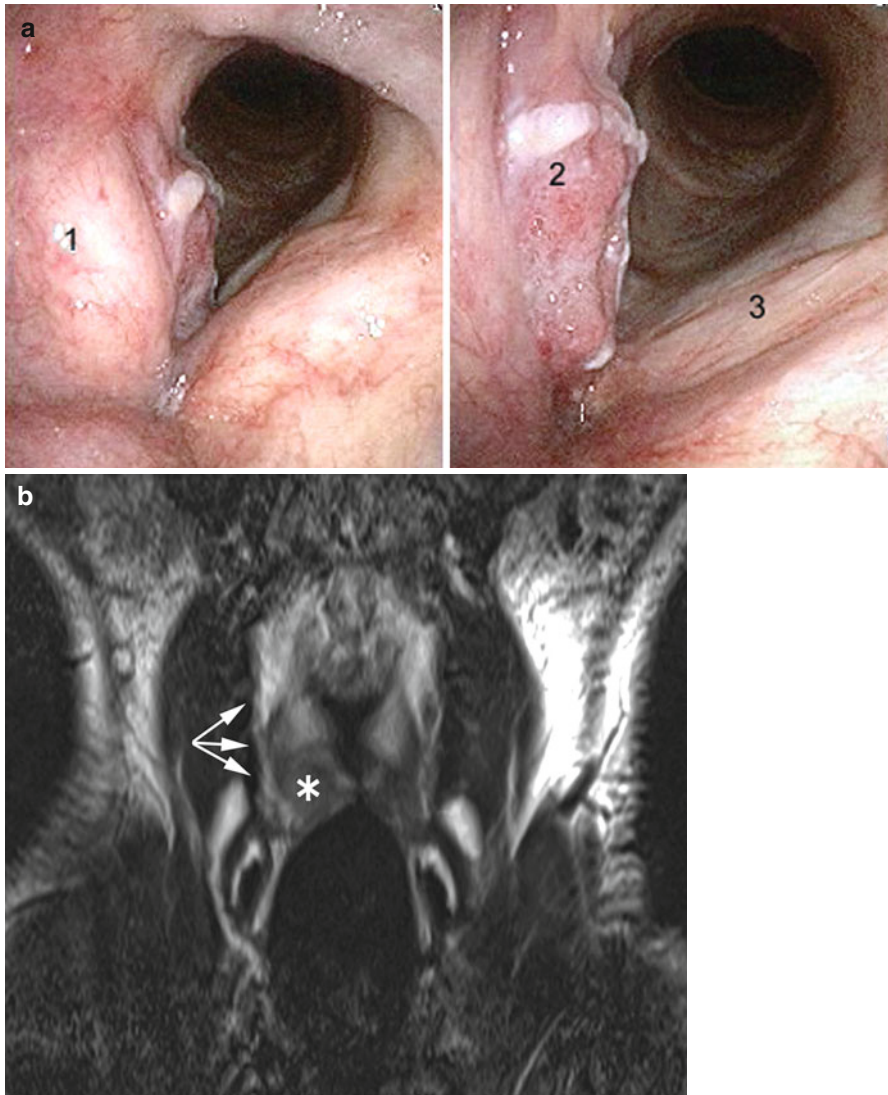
Carcinoma of the right vocal cord with vocal fold hypomobility (cT2). (a) Video laryngoscopy: vegeto-infiltrating lesion of the right vocal cord. 1 Right ventricular band, 2 tumour, 3 left vocal cord. (b) Larynx MRI: T2-weighted sequence on coronal plane. The lesion (*) infiltrates the vocal muscle and spreads within the fibres of the lateral thyroarytenoid muscle through the ventricle till the false vocal cord level. The paraglottic fat space (hyperintense stripe pointed by arrows) is not infiltrated because the lesion is contained by the thyroarytenoid muscle
